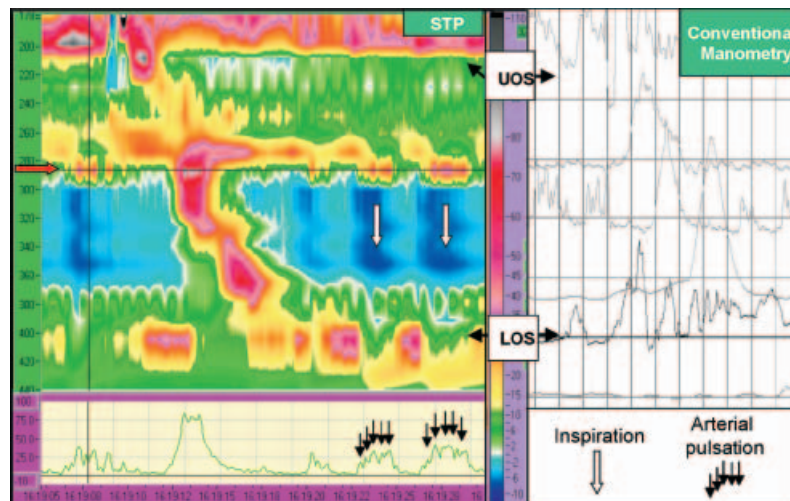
Localized abnormality of peristalsis (arteria lusoria). The 32-channel HRM from a patient with dysphagia and chest pain after swallowing. A band of raised pressure is seen 280 mm distal from the nares (red arrow). Peristalsis is interrupted by a segmental, simultaneous contraction extending to about 30 mm below this level for about 2 cms. Above this band, an area of raised ‘common cavity’ pressure is seen, suggesting fluid retention proximal to the obstruction. This was confirmed on concurrent video-fluoroscopy. The box below the spatiotemporal plot displays pressure in time at the location of the red arrow mid-oesophagus. Note the arterial pulsation (black arrows) superimposed on slow respiratory changes (white arrow). This abnormality corresponds to the position of an arteria lusoria diagnosed at CT angiography.
